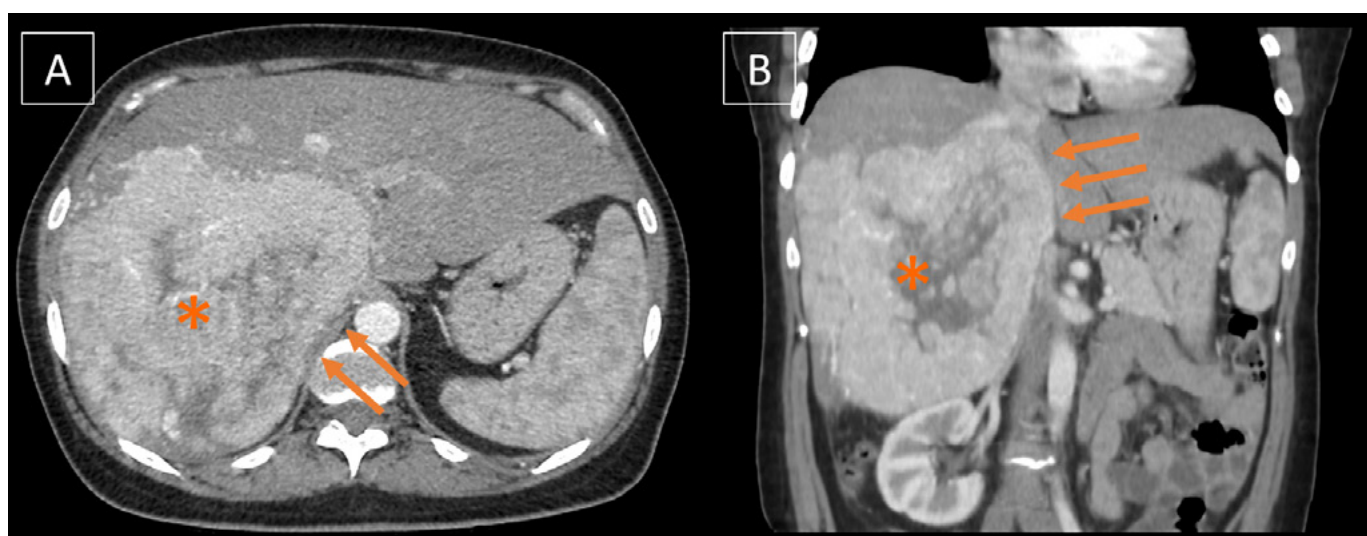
Axial (A) and coronal (B) CT scan images showing a hypervascular liver mass (\*) involving the retrohepatic IVC (arrows).
